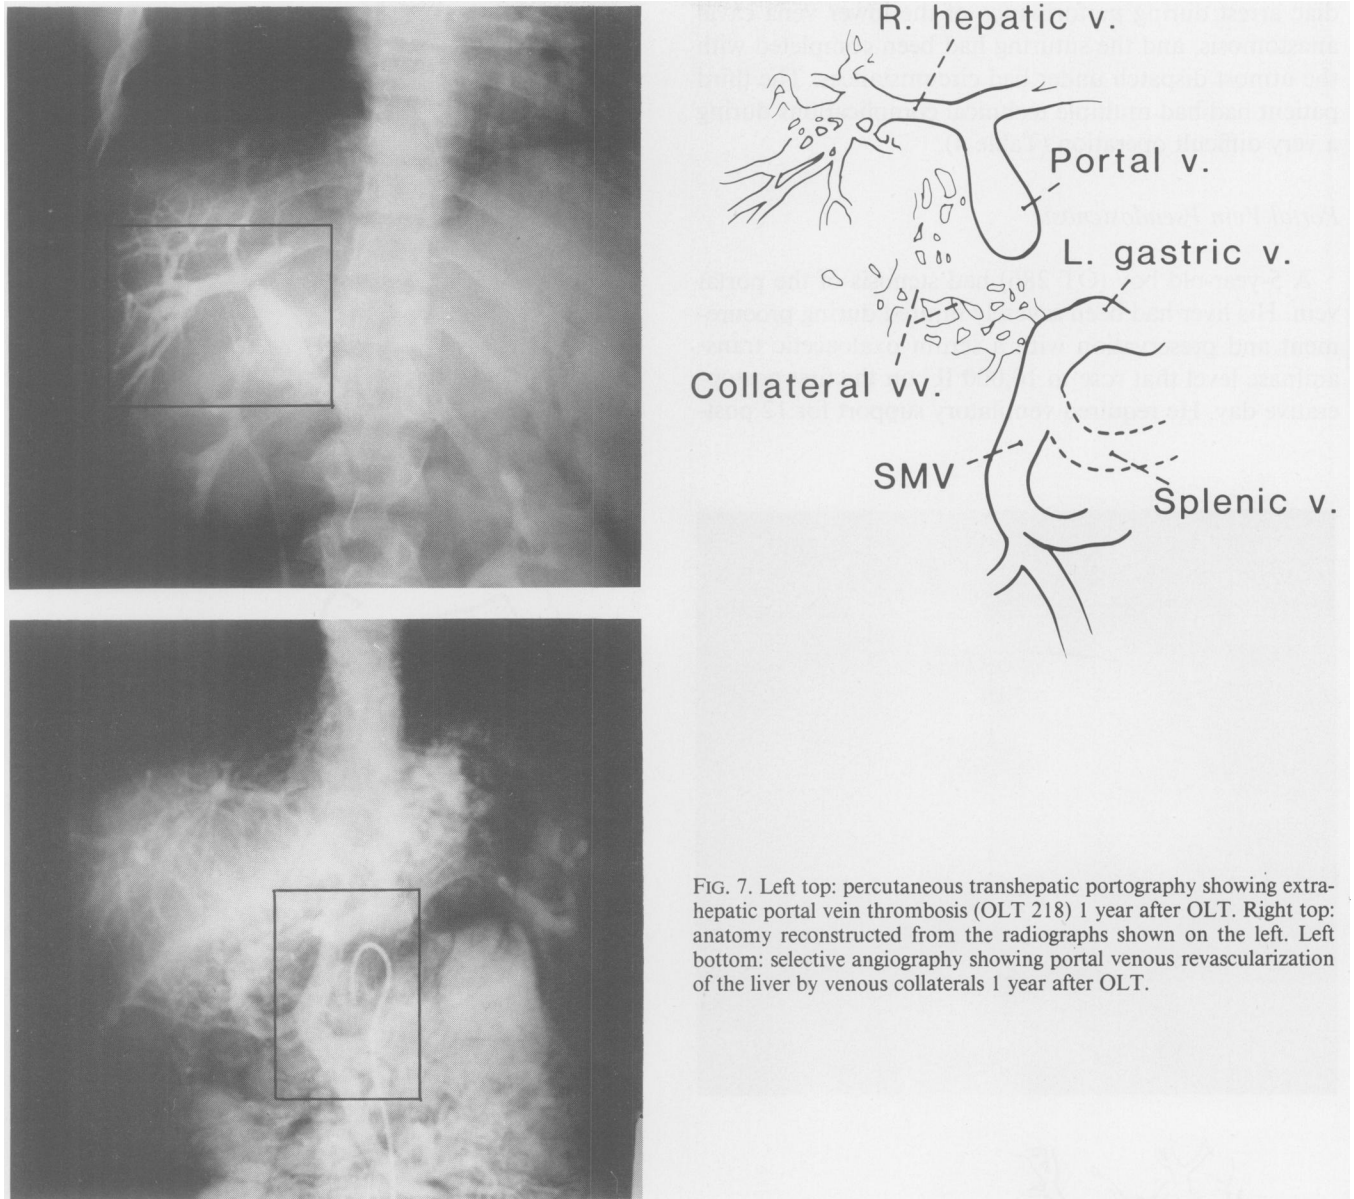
Left top: percutaneous transhepatic portography showing extrahepatic portal vein thrombosis (OLT 218) 1 year after OLT. Right top: anatomy reconstructed from the radiographs shown on the left. Left bottom: selective angiography showing portal venous revascularization of the liver by venous collaterals 1 year after OLT.
